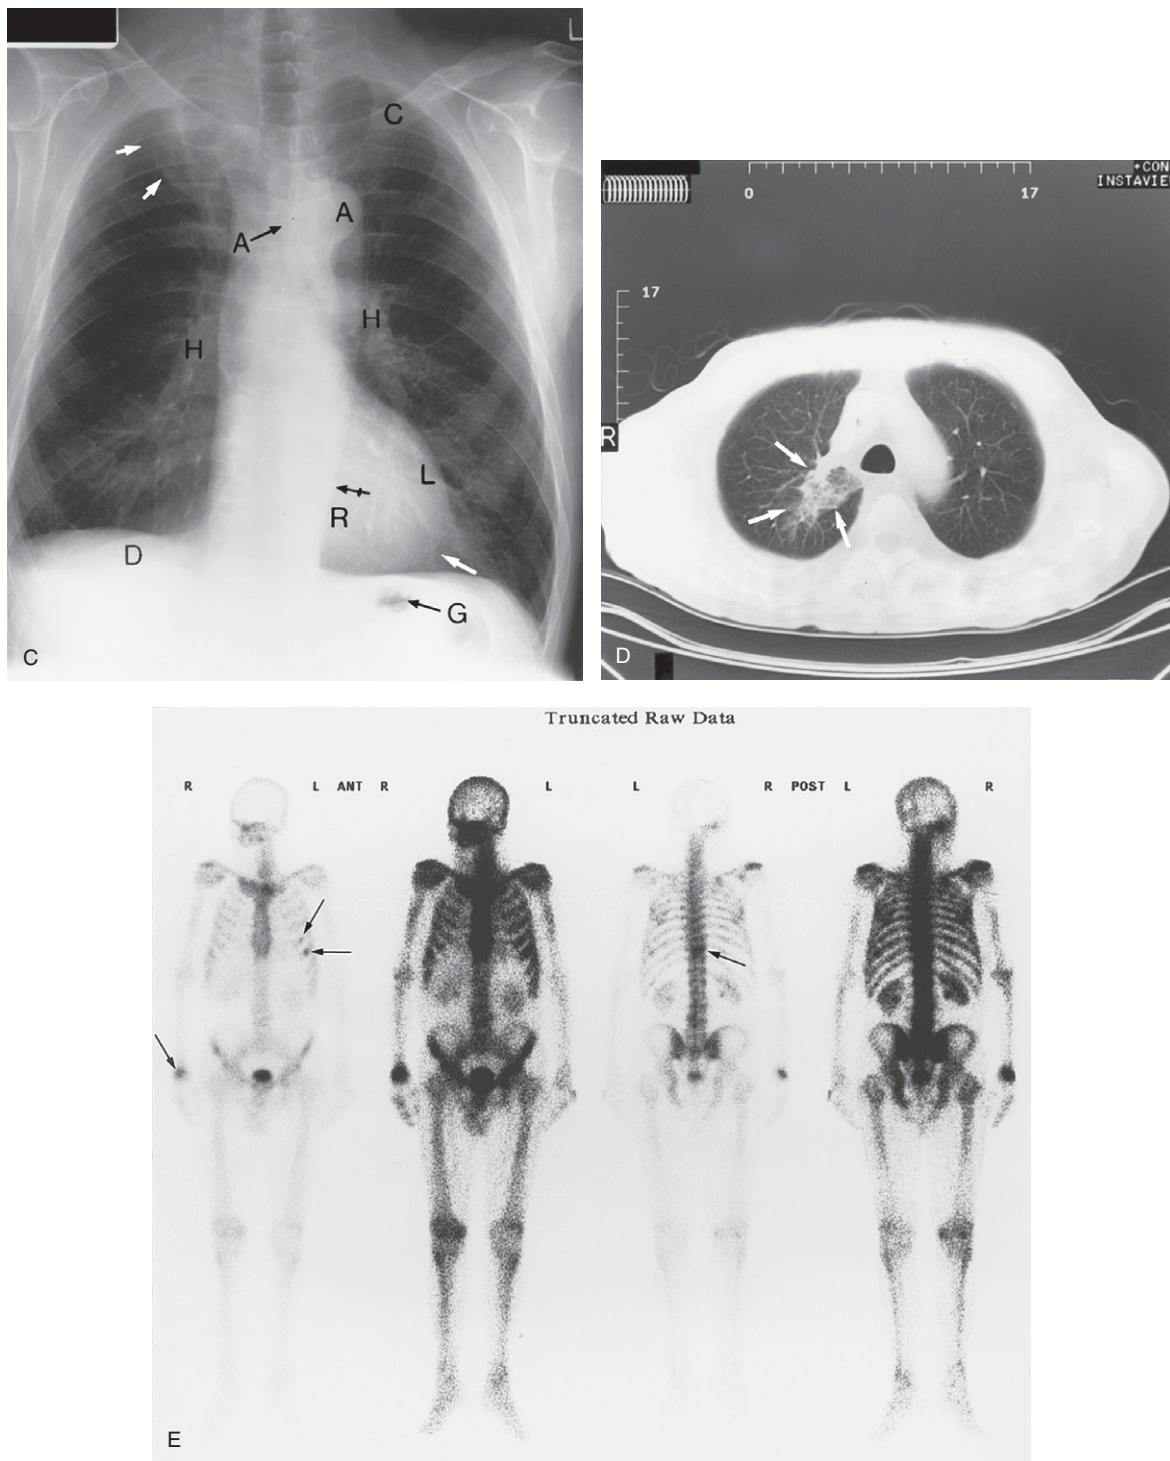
Cont'd (C) A chest posteroanterior plain X-ray view that clearly shows the Pancoast's tumour (white arrows show the approximate border) in the apex of the right lung. A = aortic knuckle; D = dome of right diaphragm; A arrow = aortic arch; L = left ventricle; H = hilar shadow; C = clavicle; single white arrow = apex of the heart; tailed black arrow = descending thoracic aorta; G = gas in the upper part of the stomach ('magenblase'). (D) A CT scan of the chest showing the Pancoast's tumour on the right side (arrows). (E) Whole body bone scan truncated raw data. Arrows show areas of increased tracer uptake.
